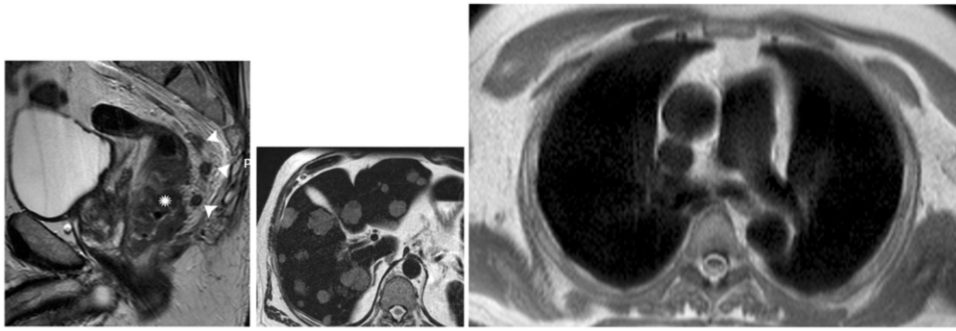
"Whole Body USPIO enhanced MRI is a promising tool for one-shop-stop staging of rectal cancer patients ": (left) Sagittal T2W FSE MR image of a male patient shows a distal rectal tumour (white asterisk) with suspected mesorectal lymph nodes (white arrowheads). (mid, right) Axial T2W MR images of the same patient of the liver and lungs show multifocal liver lesions suspected for metastases and no lung metastases.
